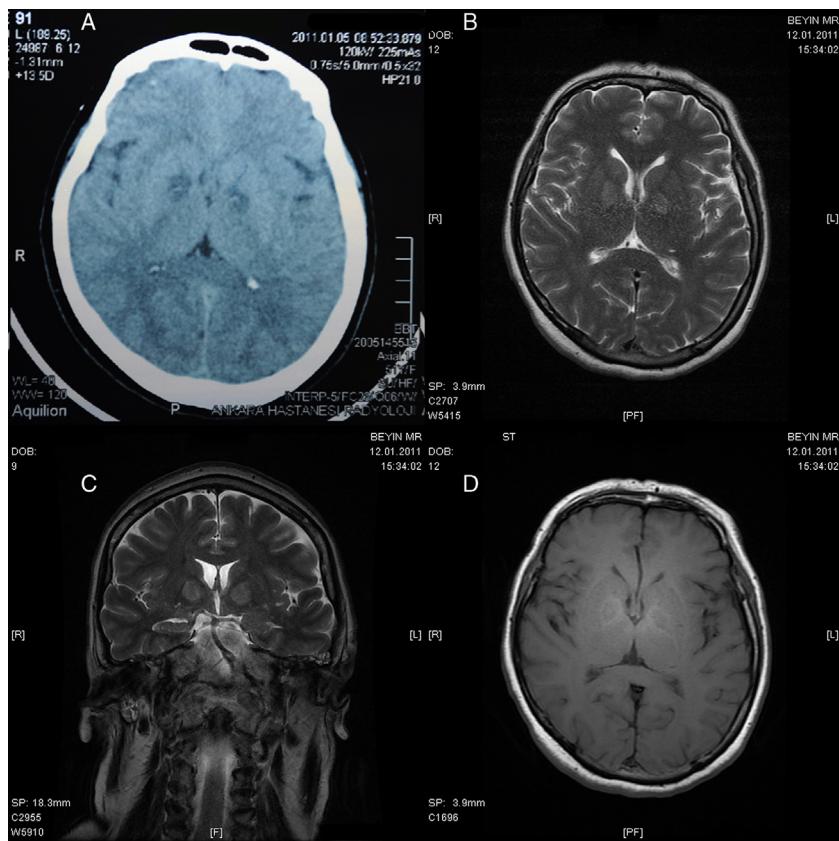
(A) Axial CT, (B) axial T2 MRI, (C) coronal T2 MRI, and (D) axial T1 MRI of Case 1.
